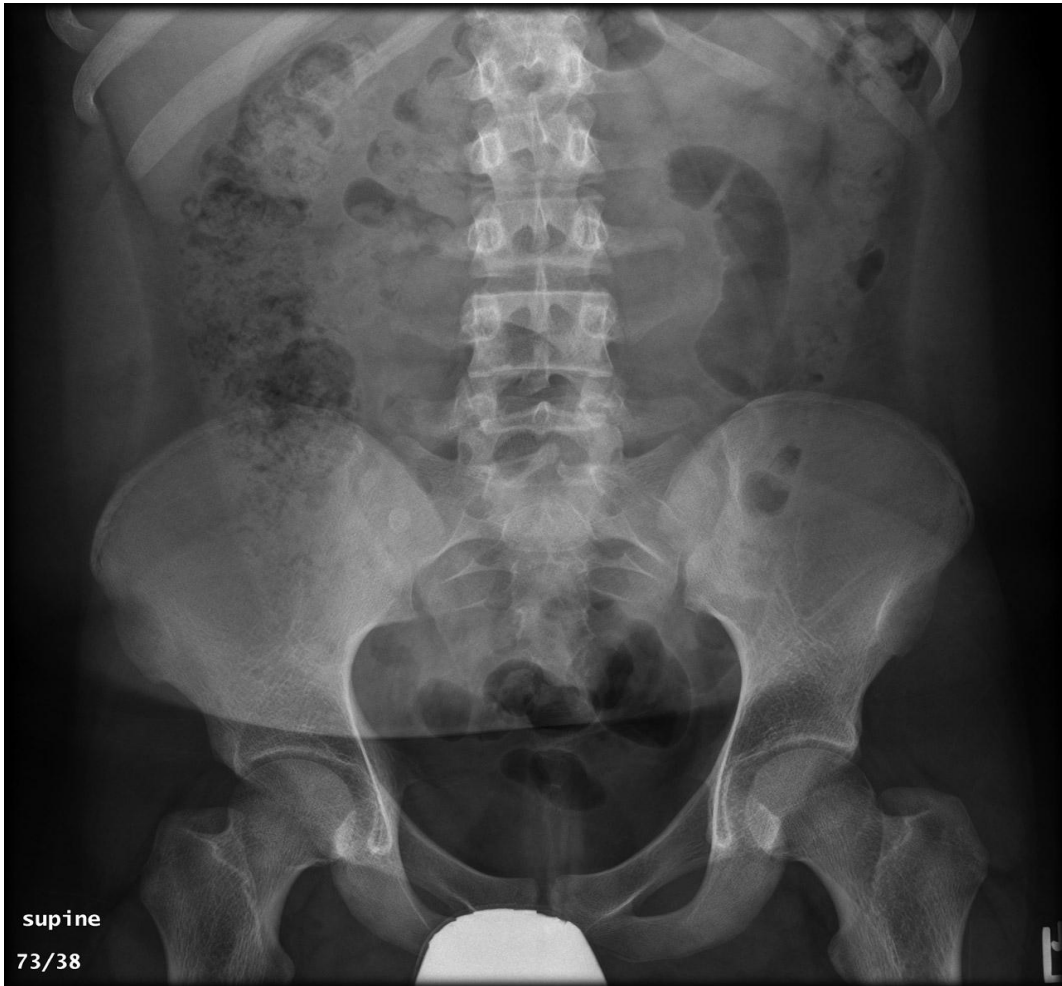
X-ray abdomen erect AP - Showing appendicolith
